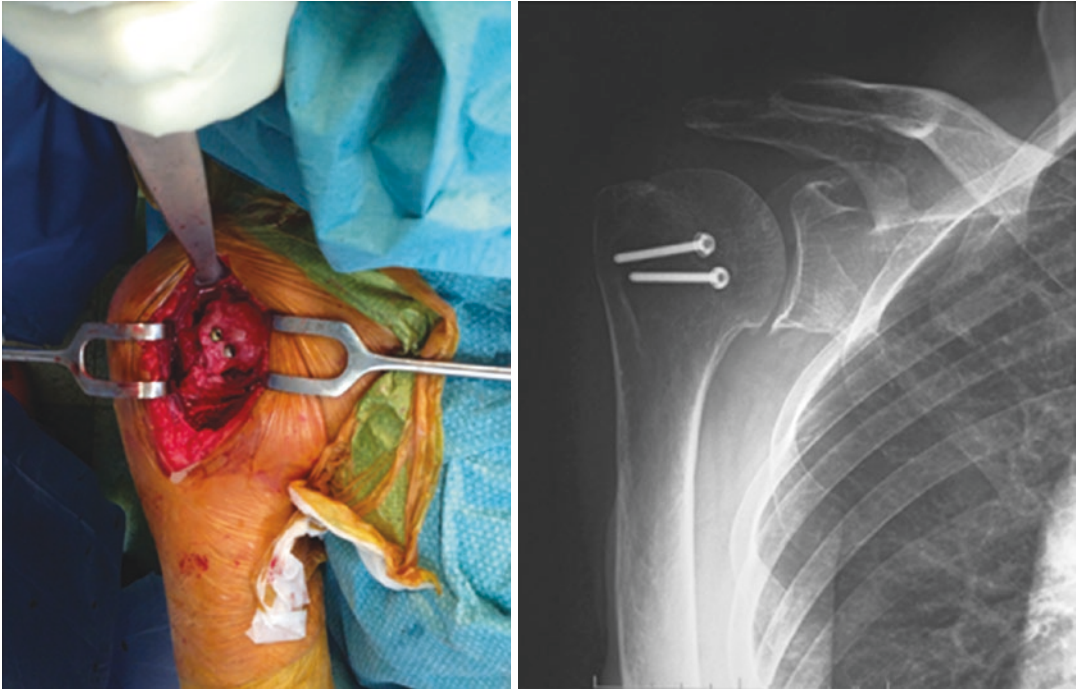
Transfer of the subscapularis tendon into the bone defect and stabilization with two screws (McLaughlin technique): intraoperative image and post-operative X-ray
